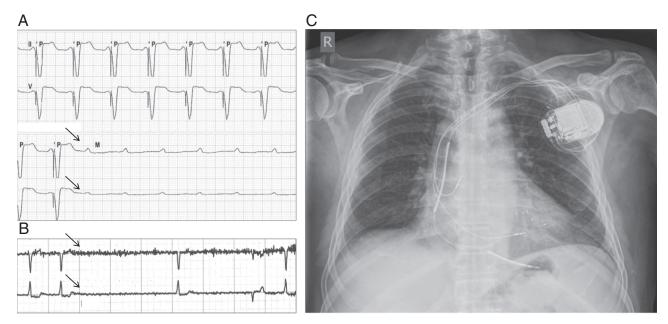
Representative cardiac telemetry recordings show failure of pacing (arrows) the day after device implantation in A: case 1 and B: case 2. C: A posteroanterior chest x-ray showing the 3 leads in situ at the locations documented at implant for case 2.
